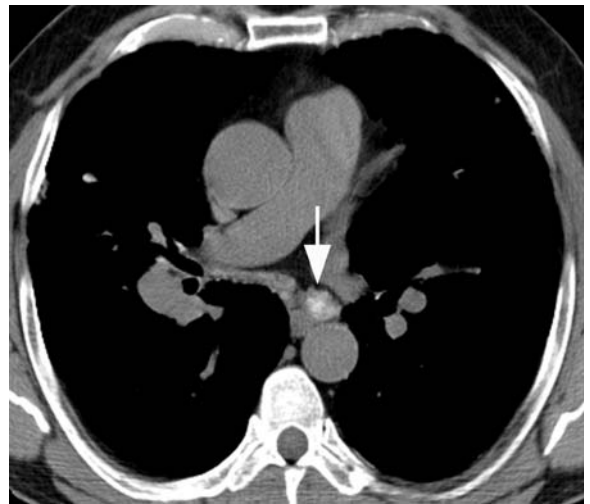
Computed tomography through the subcarinal region in a patient with chronic beryllium disease shows right hilar enlargement due to adenopathy. A mildly enlarged left subcarinal node (arrow) shows an amorphous pattern of calcification
